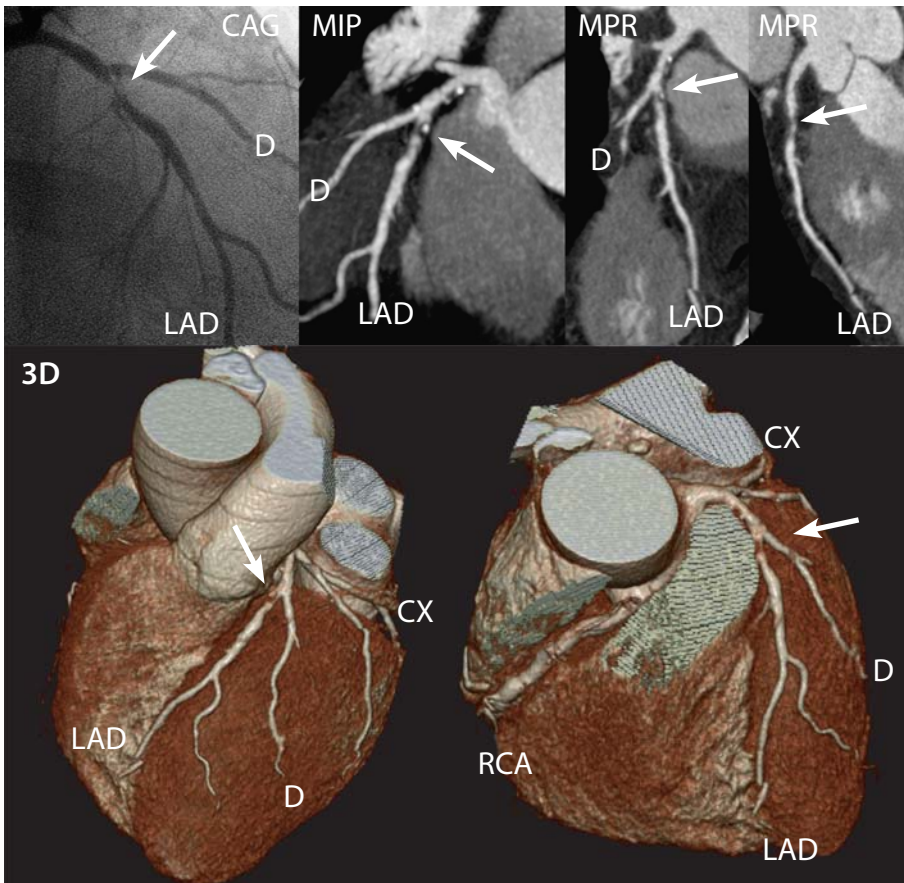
A lesion in the LAD examined with 16-slice CT. Severe narrowing (*arrow*) of the LAD by a partially calcified plaque. Just distal from the first large diagonal branch, the lesion can be visualized using maximum-intensity projection (MIP), curved multi-planar reformation (MPR), and VRT (*bottom images*). It was confirmed by conventional coronary angiography (CAG)
